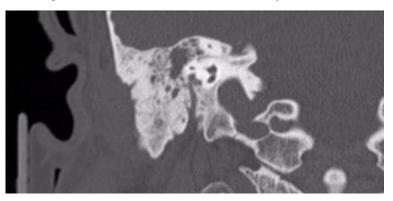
CT scan of the right internal auditory canal - coronal view
